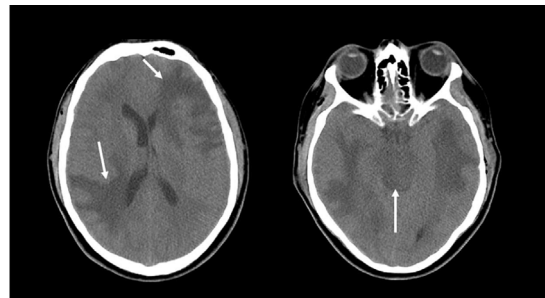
Axial sections of a non-contrast CT head exam reveal ill-defined intracranial lesions with surrounding edema, the largest in the right temporal lobe, left frontal lobe, and pons (white arrows).
